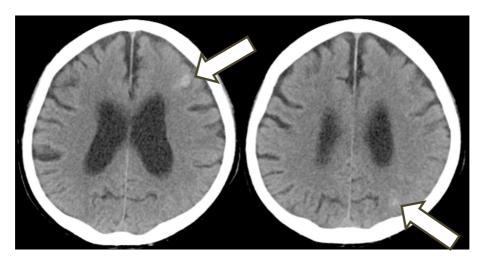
Head CT scan images without contrast enhancement. Non-enhanced CT of the brain showed subarachnoid hemorrhage in the left frontotemporal portion.
